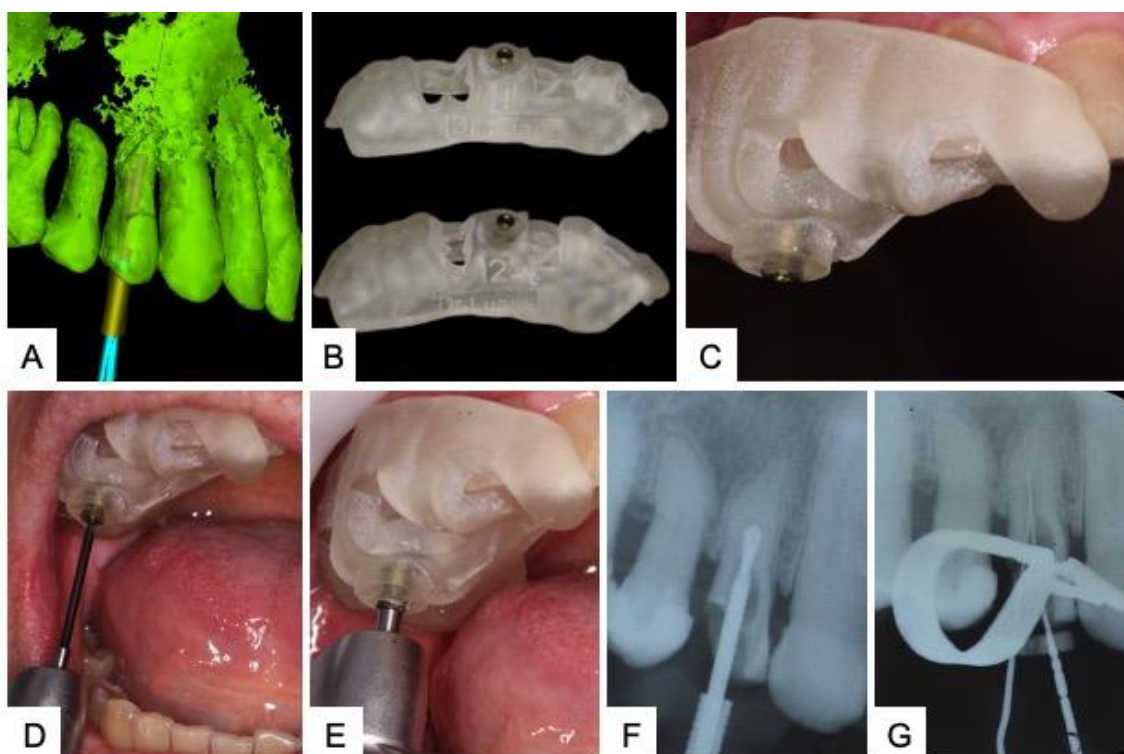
A – Digital planning with a bur overlapping scan and tomography images; B – 3D-printed guides; C – Guided endodontic access positioned and adapted in the patient's dental arch; D – 103.395 access bur in a working position; E – Burs on the pre-established working limit in digital planning; F – Periapical X-ray showing bur length after touching the guide metal sleeve; G – Periapical X-ray showing exploratory files within the canals for working length determination.
